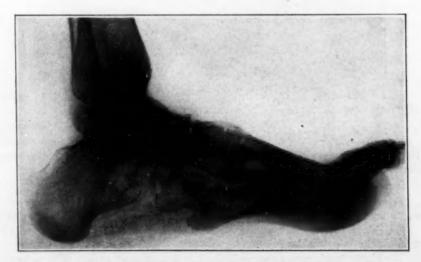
(case 7).—Roentgenogram showing lateral view eight months after subastragalar arthrodesis for cavus deformity.
